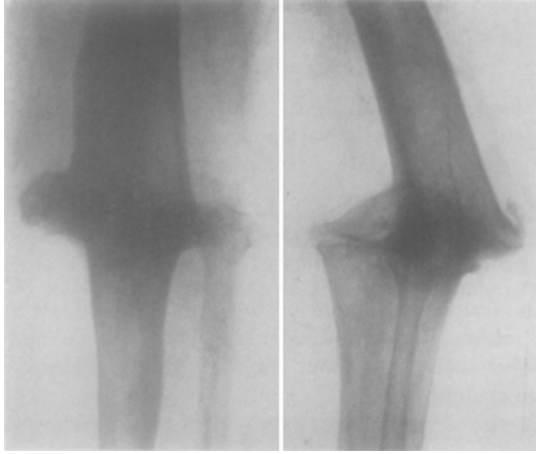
Case 5: roentgenograms of right knee; ankylosis after arthrodesis.
